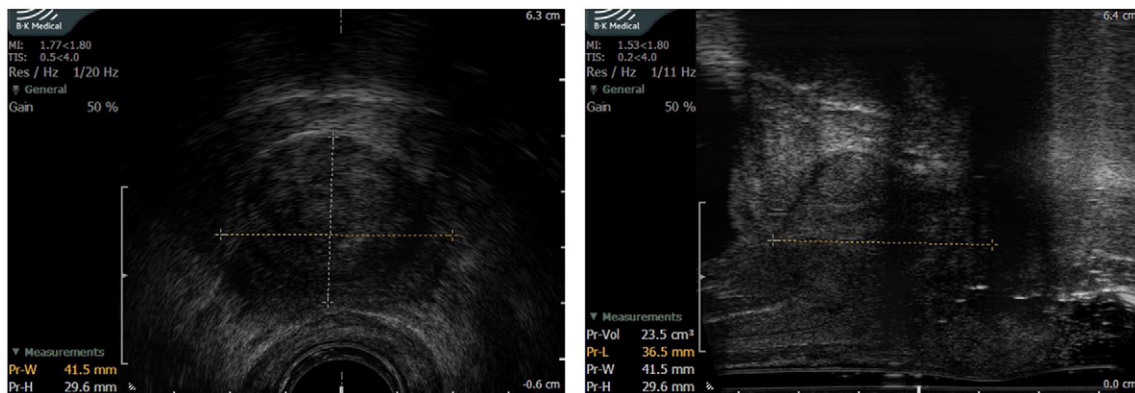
Transrectal ultrasound volume study pre-implantation axial and coronal images. The urethral tumor displays a remarkable resemblance to a typical prostate gland. The dimensions of the tumor are displayed in the lower left of the images.
